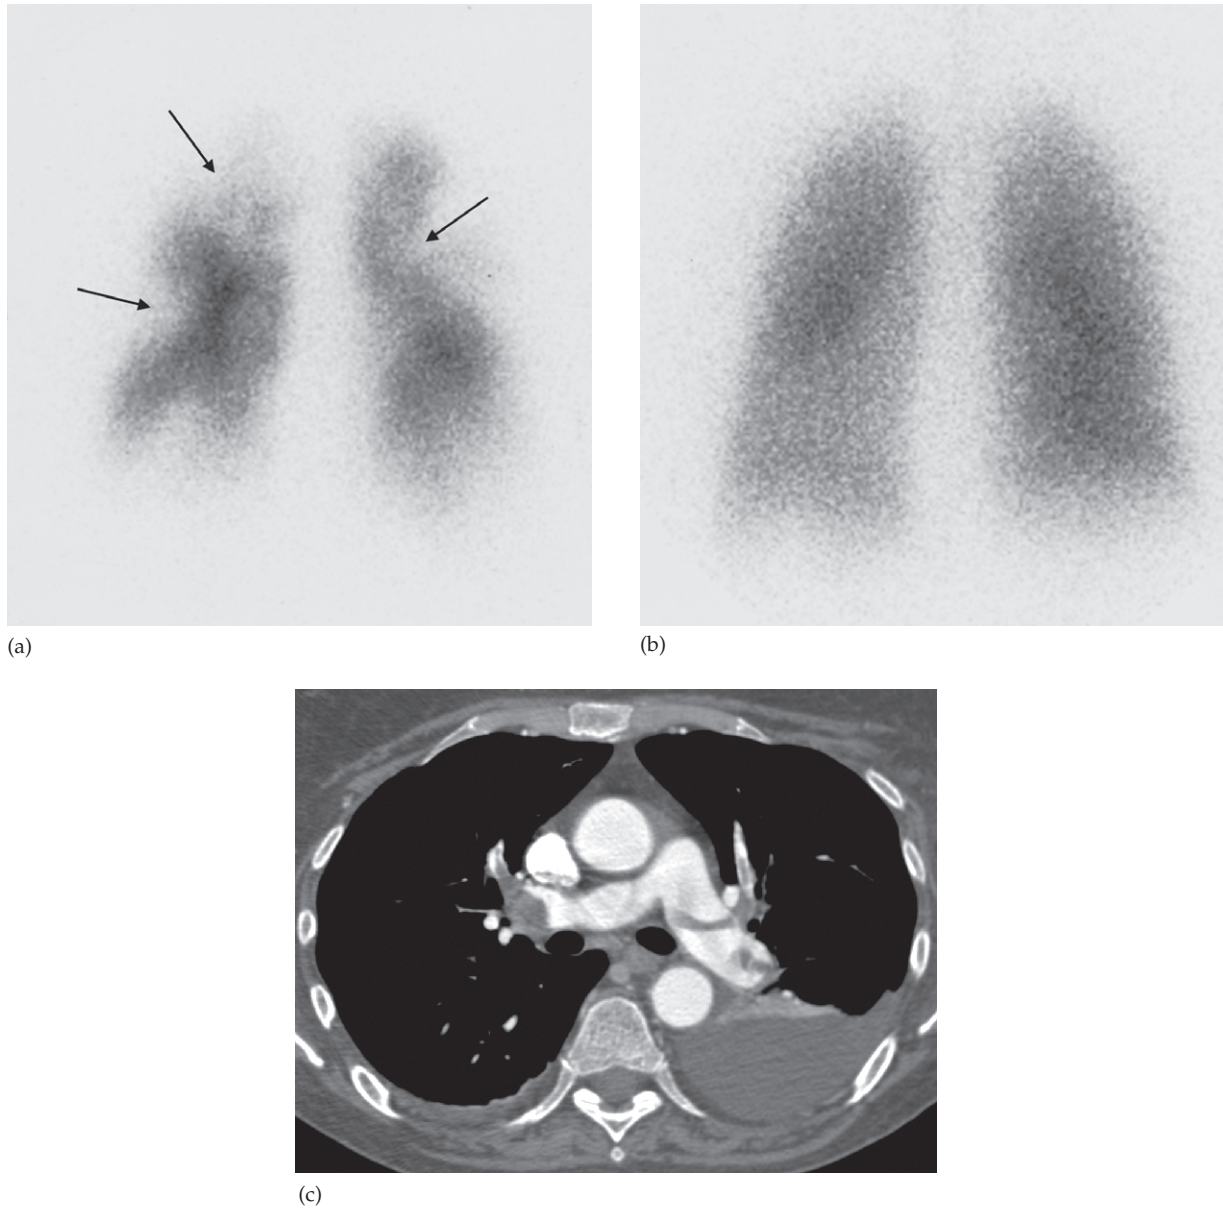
Pulmonary emboli. (a) ^{99m}Tc macroaggregate perfusion scan (posterior view) showing multiple wedge-shaped defects. The more obvious ones have been arrowed. (b) The ventilation scan, using ^{81m}Kr (also a posterior view), is normal. (c) CT pulmonary angiogram showing bilateral filling defects due to emboli in the central pulmonary arteries (arrow).
